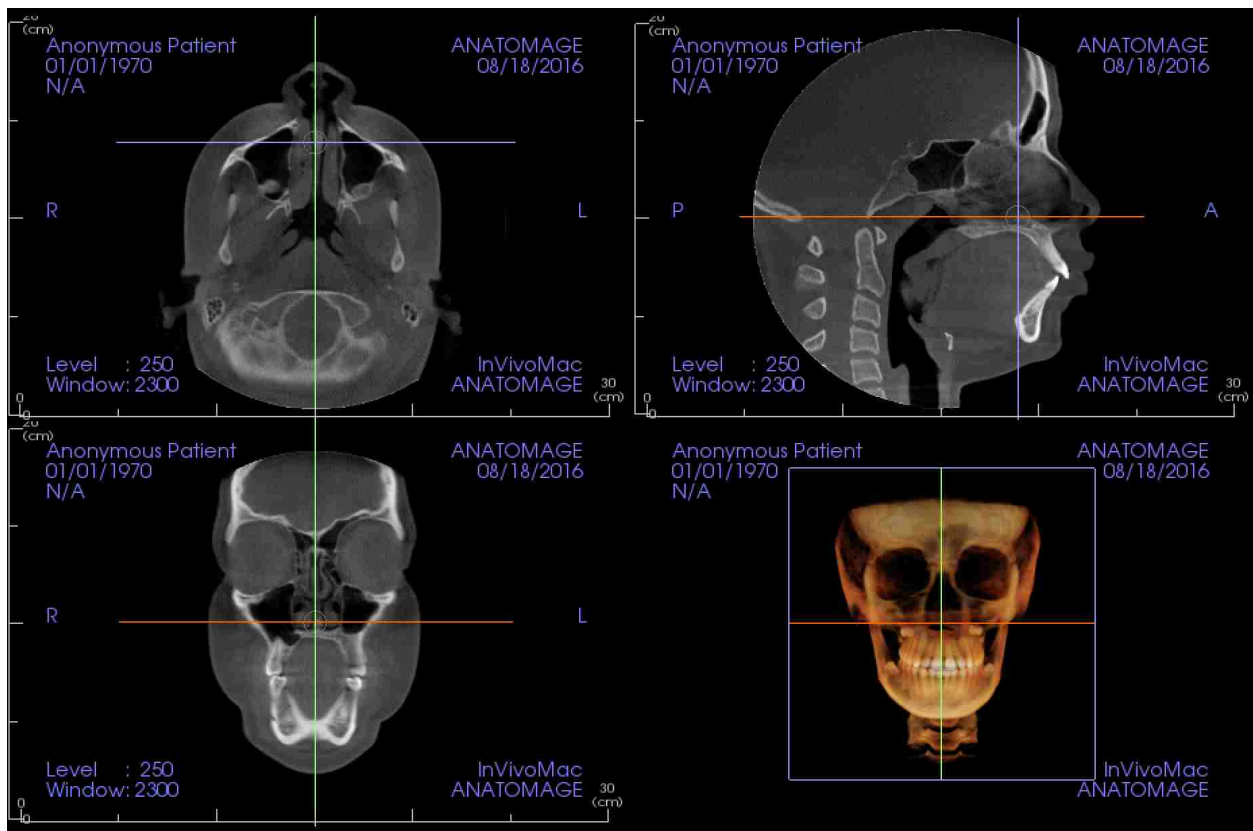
Orientation of CBCT Images for Analysis in Midsagittal Plane
